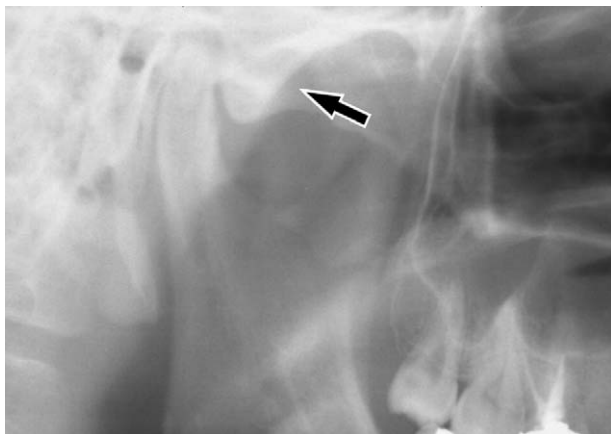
The right articular eminence of the panoramic radiograph is shown (arrow). The fracture is not seen in the eminence.
